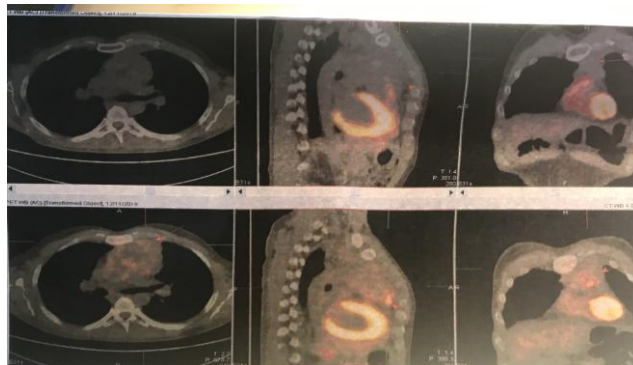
Comparative images from PET-CT before and after radiotherapy (upper part of a picture is PET-CT showing results after radiotherapy)
